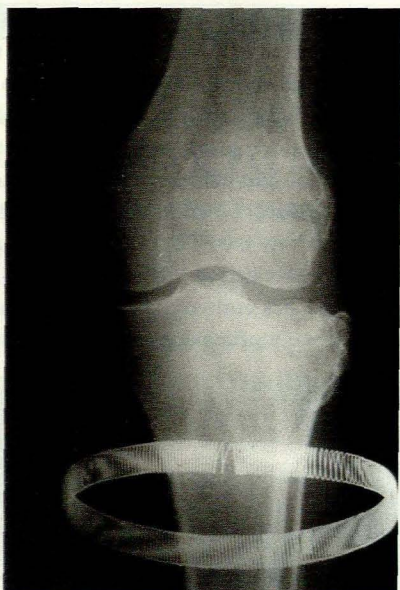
Repeat radiograph of the left knee showing filling of the previously lucent area involving the tibial plateau.
